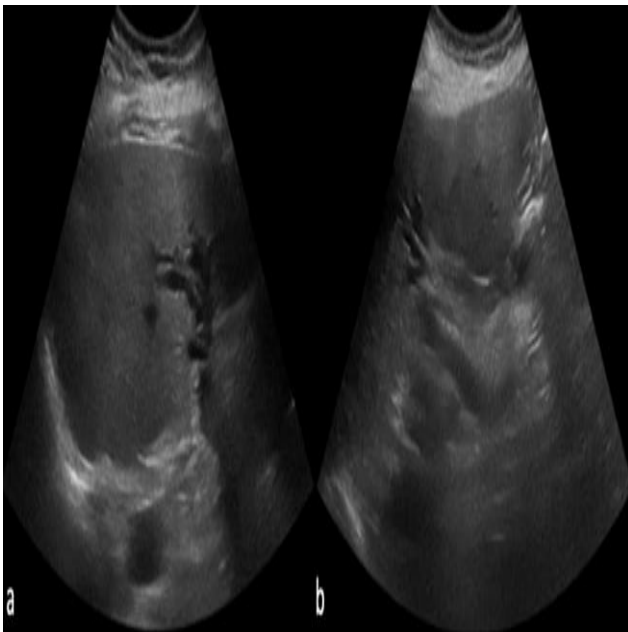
(A and B): Transverse ultrasound image shows bilobar intrahepatic biliary radical dilatation. Longitudinal ultrasound image shows normal echotexture of the visible head of the pancreas.
